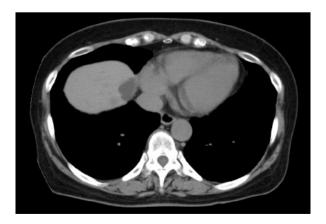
Abdominal computed tomography image showing a hepatic cyst and dilation of the distal lower third of the esophagus
